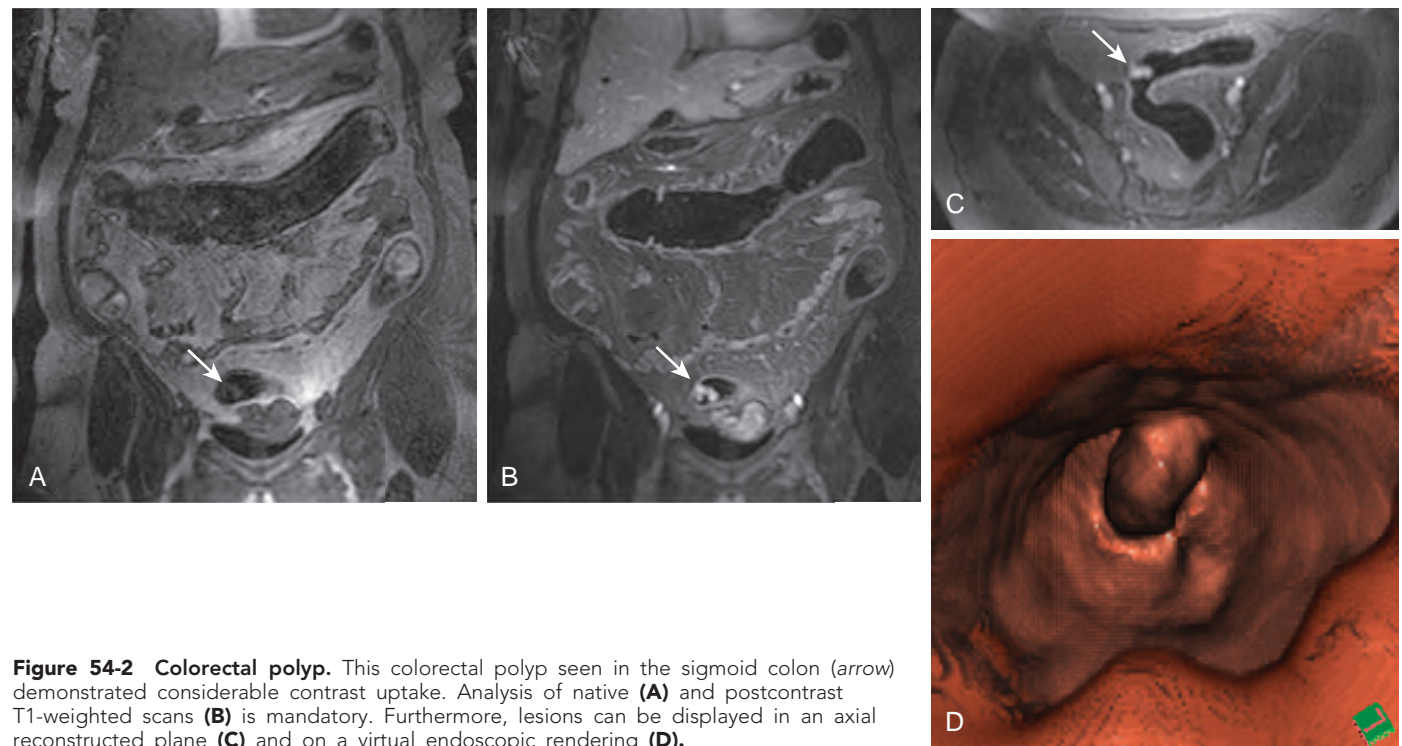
Colorectal polyp. This colorectal polyp seen in the sigmoid colon (arrow) demonstrated considerable contrast uptake. Analysis of native (A) and postcontrast T1-weighted scans (B) is mandatory. Furthermore, lesions can be displayed in an axial reconstructed plane (C) and on a virtual endoscopic rendering (D).
